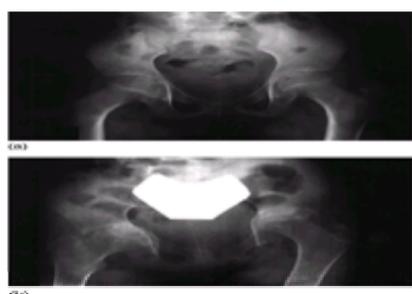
Girl with systemic-onset juvenile chronic arthritis since 7 years. Hip radiographs show: (a) At 33 months after disease onset, osteopenia, joint space narrowing, and erosions. (b) At 4.5 years after disease onset, increased loss of joint space, protrusio acetabulae, subchondral irregularity and erosions, and sclerosis of both sides of the joints. There is also flattening of the left femoral head.
